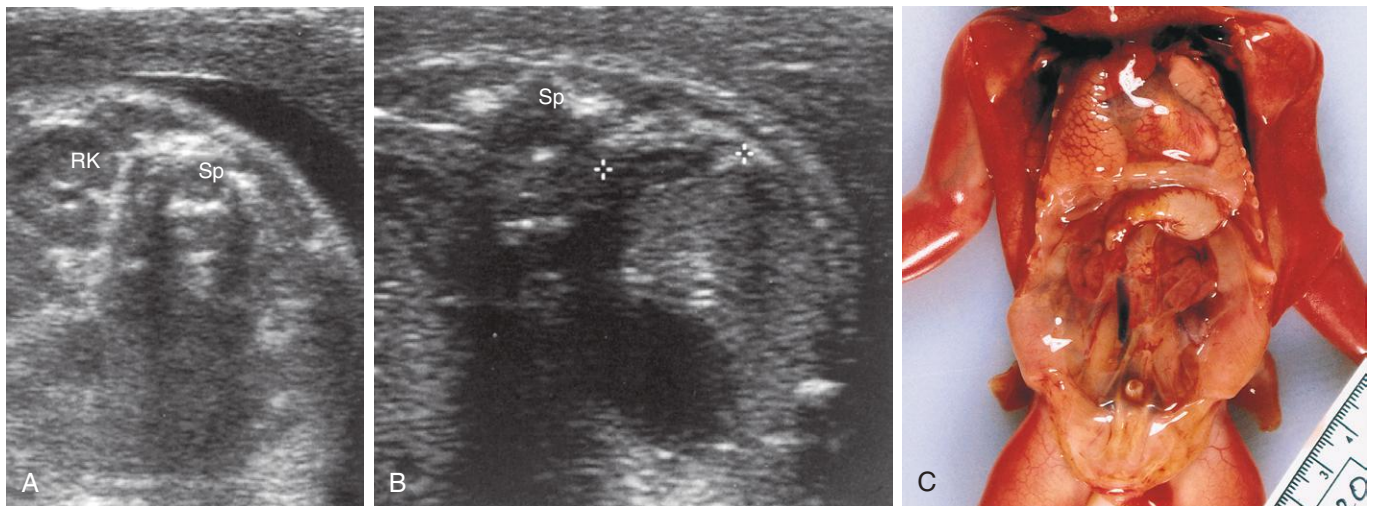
Sonograms of a fetus with unilateral renal agenesis. A, Transverse scan at the level of the lumbar region of the vertebral column (*Sp*) showing the right kidney (*RK*) but not the left kidney. B, Transverse scan at a slightly higher level showing the left suprarenal gland (between cursors) within the left renal fossa. C, Dissection of a male fetus of 19.5 weeks with bilateral renal agenesis. (*A and B*, From Mahony BS: *Ultrasound evaluation of the fetal genitourinary system*. In Callen PW, editor: *Ultrasonography in obstetrics and gynecology*, ed 3, Philadelphia, 1994, Saunders.)
